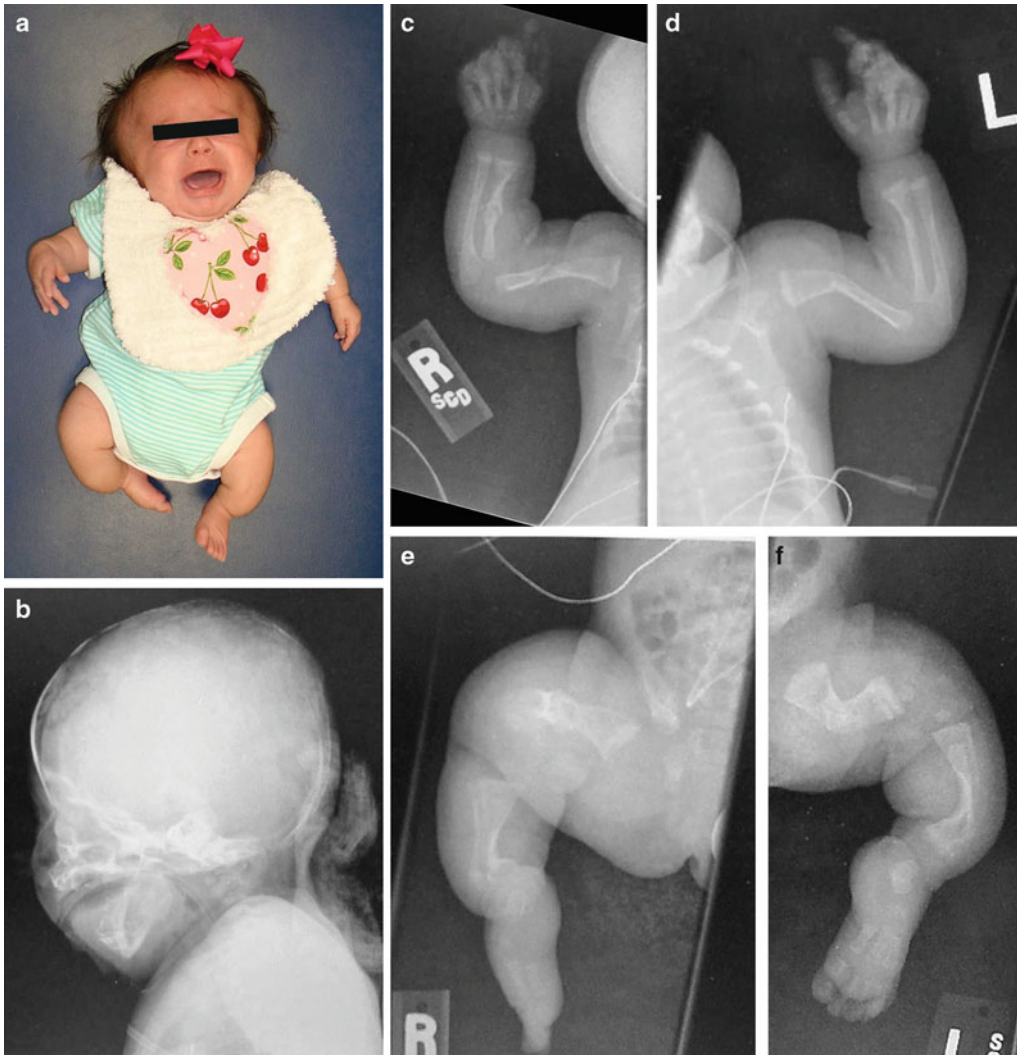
(a–f) A neonate with osteogenesis type III showing short-limbed dwarfism, large head, short neck, and short and curved upper and lower extremities. Radiographs showed generalized osteopenia, poor mineralization of the skull, and short and bowed limbs with multiple fractures with callus formation. Molecular study by sequence analysis indicated a variation in the fragment containing
